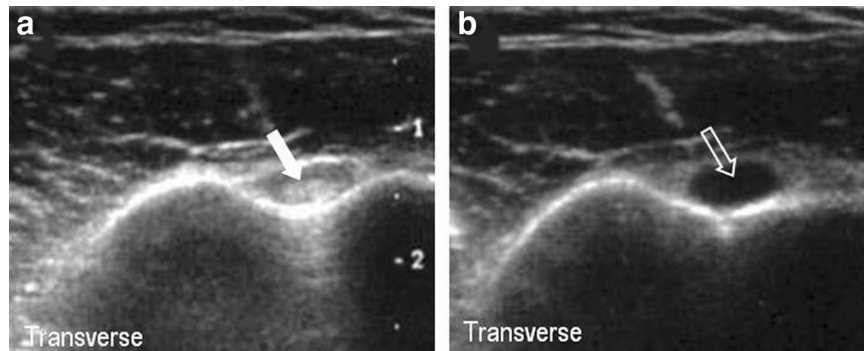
Anisotropy of normal biceps tendon. a, Transverse sonogram of hyperechoic biceps tendon (arrow) when the ultrasound beam is perpendicular to the tendon. b, Hypoechoic biceps tendon (open arrow) when the ultrasound beam is not perpendicular to the tendon.
